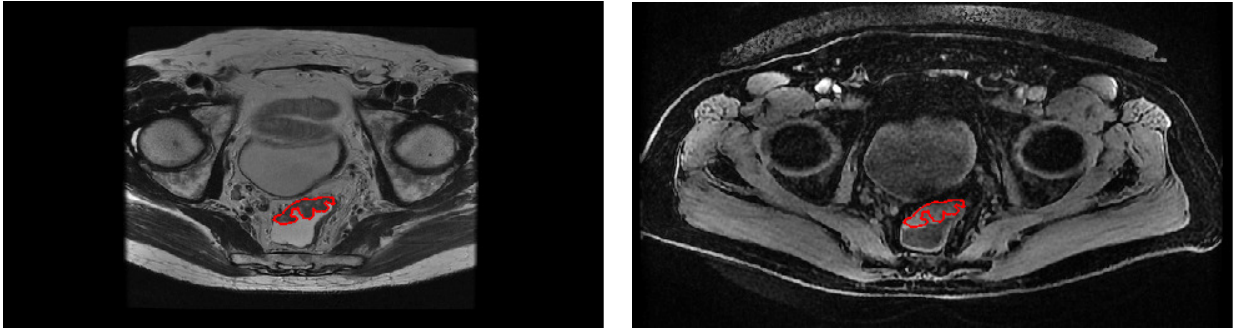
Image registration was performed to translate the tumour VOI delineated on the diagnostic $T2$ -weighted image onto the DCE-MRI image. (Left) Slice through the $T2$ -weighted image with superimposed tumour delineation (Right) Slice through DCE-MRI image after registration, with mapped tumour delineation superimposed*
